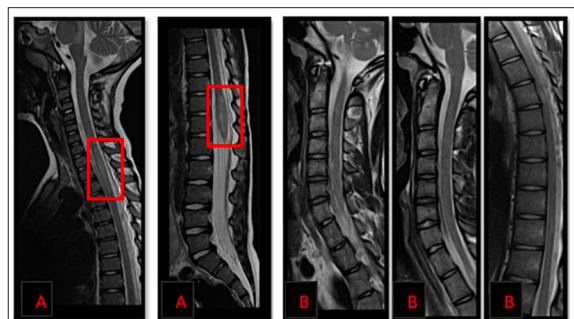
Pediatric myelopathies secondary to demyelinating diseases (sagittal T2-weighted images). (A) ADEM: A 4-year-old patient presenting with encephalopathy and extensive spinal cord signal changes involving the central cord from C7 to D4, as well as the conus medullaris. (B) MS: A 16-year-old patient with motor and sensory deficits. MRI shows typical multiple, small, and short-segment lesions (each <3 vertebral segments) at the cervical level (C5) and dorsal levels (D2-D3, D5-D6, and D9-D10).
